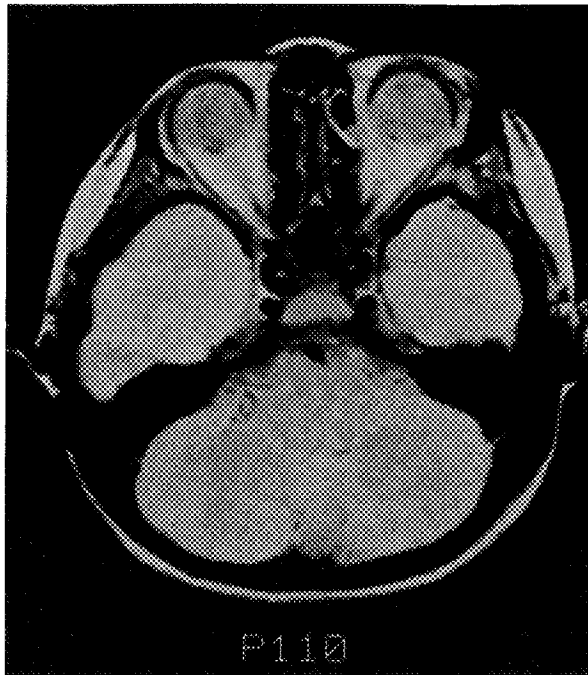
T2-weighted image of Patient 2 on the slice corresponding to the optic canal. That there is no compression on the optic nerve is clearly shown.
